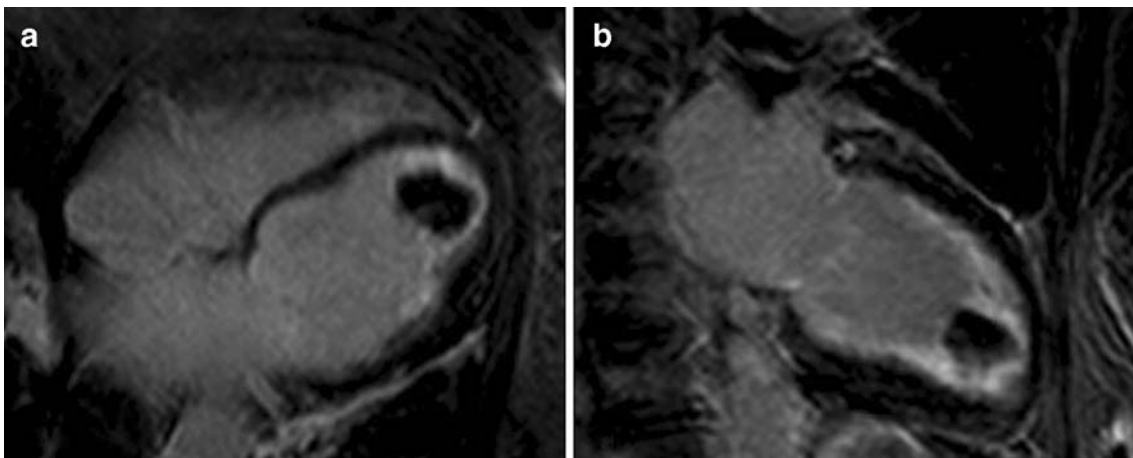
Gadolinium delayed enhanced viability magnetic resonance images. Apical large nonenhancing thrombus formation and the intense linear enhancement of the endocardium can be identified. Four-chamber (a) and two-chamber (b) images.
